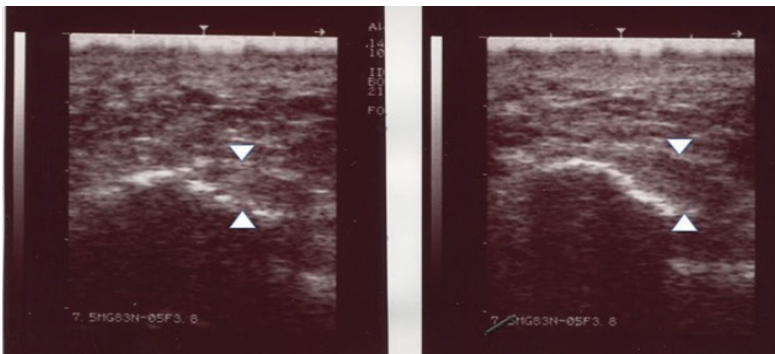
Ultrasound scan, clinical case 1: the follow-up ultrasound scan shows the normalisation of the calcaneal insertion of the plantar fascia. There is no evidence of overdilatation of the bursae.
